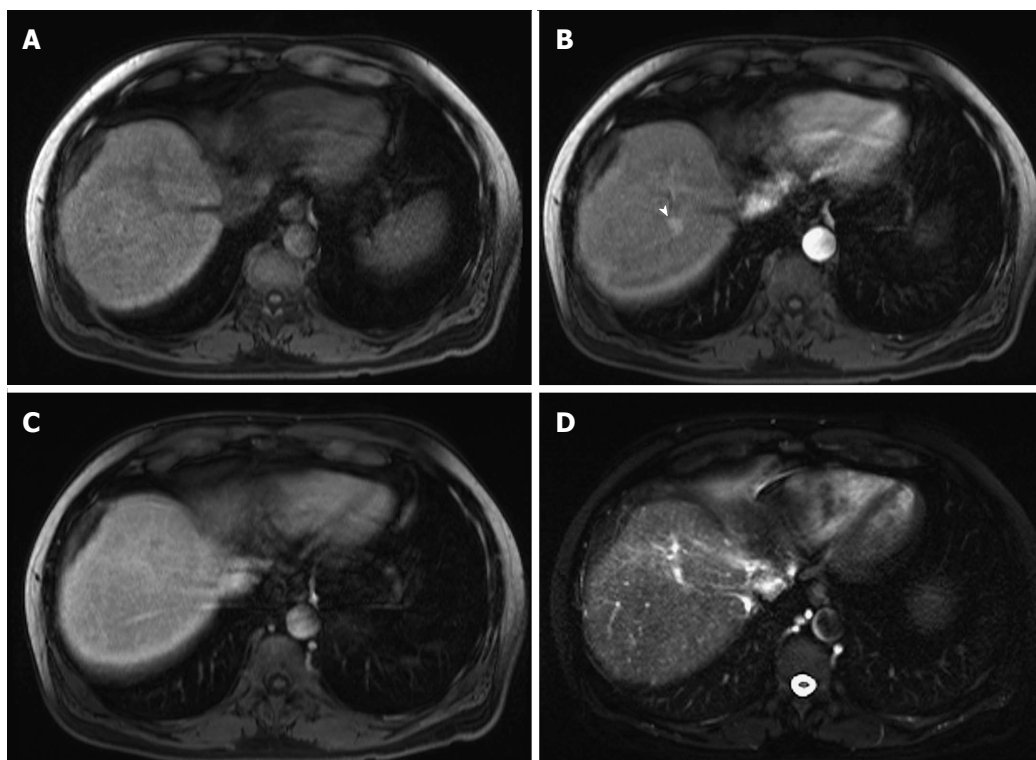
High-grade dysplastic nodules. Pre- (A) and post-contrast fat-suppressed 3D-GRE T1-weighted images during the (B) Late hepatic arterial; and (C) Delayed phases; (D) Fat-suppressed SSFSE T2-weighted image. There is a nodule at hepatic segment #7, which demonstrates iso T1 signal intensity (A), increased arterial enhancement (arrowhead, B), without definite washout or corresponding T2 signal abnormality in keeping with a HGDN. However, early HCC cannot be totally excluded and short-term follow-up should be recommended, especially in patients with hepatitis C infection. HGDN: High-grade dysplastic nodules; HCC: Hepatocellular carcinoma; GRE: Gradient recalled echo; SSFSE: Single-shot fast spin-echo.
